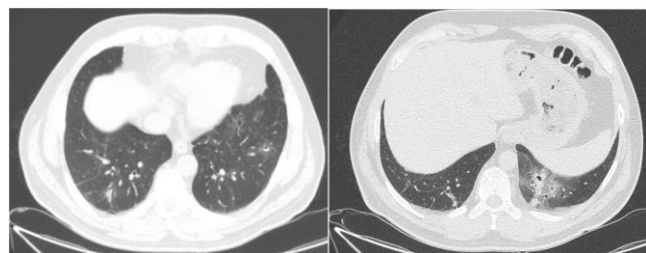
Axial chest CT images revealing pulmonary hemorrhage, presenting as patchy areas of ground glass opacity and consolidation in both lower lobes, and multiple pneumatoceles 3–9 mm in size within the areas of pulmonary hemorrhage
